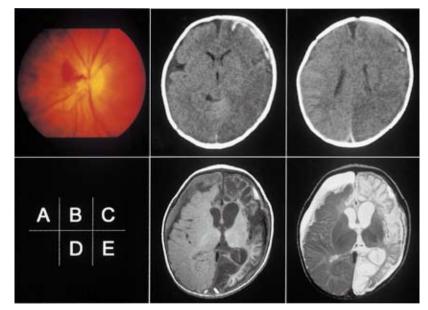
A: In the fundus examination performed on seventh day from admission, diffuse preretinal bleeding was observed. B, C: Brain CT on admission, revealed a subdural hematoma along the cerebral falx and extensive cerebral edema on the area of left occipital region. D, E: At 2 months after the onset, a head MRI T1-weighted image (D) and T2-weighted image (E) showed images of subdural hematoma and cerebral atrophy in the right front temporal area. The left side showed a finding of severe multiple cystic encephalomalacia.
